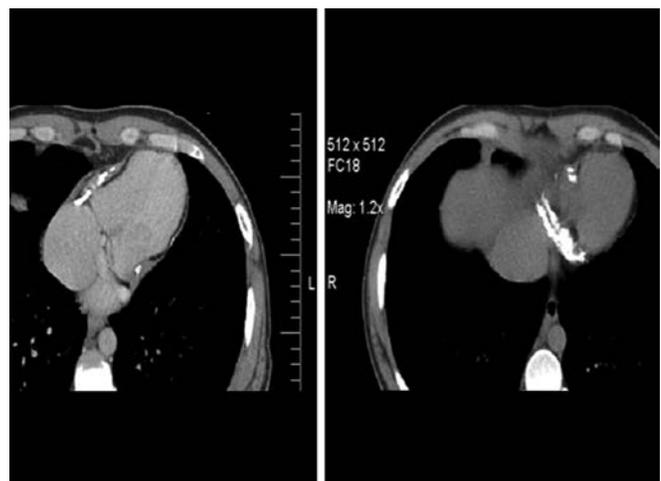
CT scan shows calcified pericardium.
